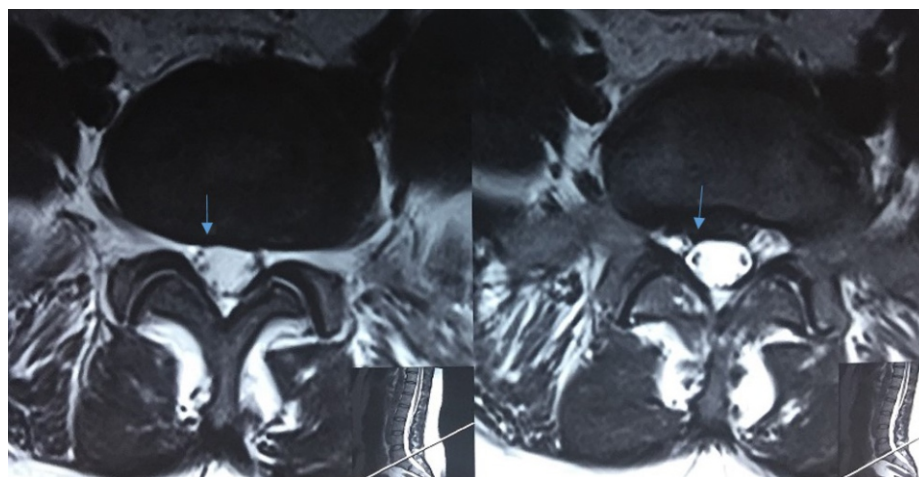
Axial T2 wt MRI images showing resolution of the prolapsed disk (arrows).
